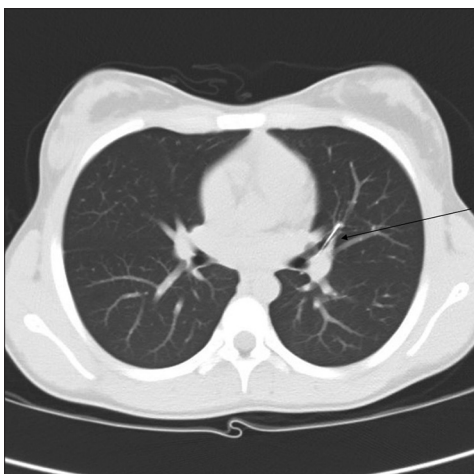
CT chest showing sharp pin in left bronchus piercing the lung parenchyma
